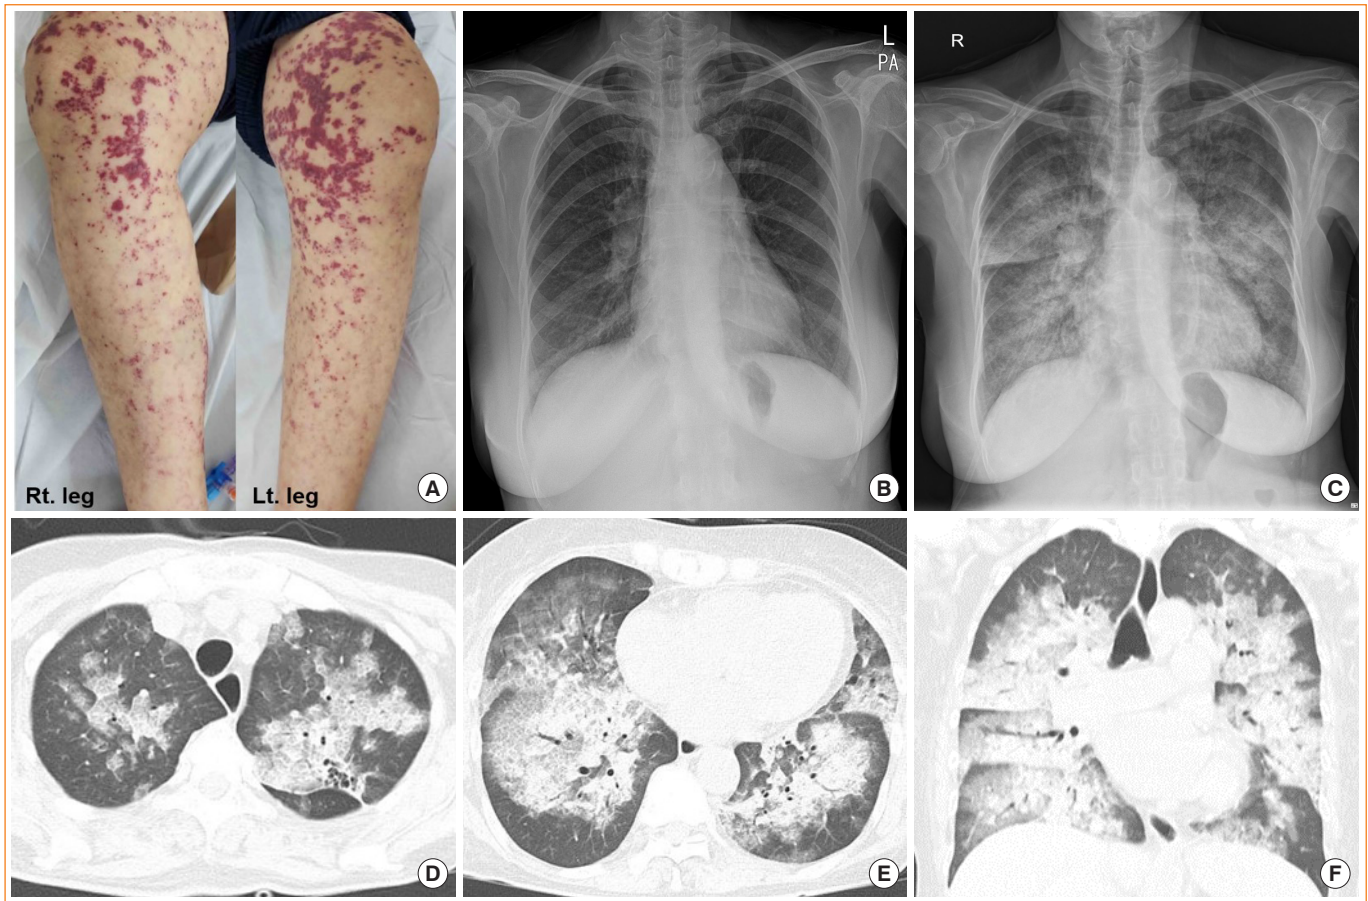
The representative images of the patient. (A) Representative images of skin lesion showed that blanching erythematous skin lesions are present on her bilateral lower extremities. (B) Initial chest X-ray at admission was normal. (C) Chest X-ray at the time the patient's symptoms worsened showed diffuse haziness in both lung fields. (D, E, F) Representative coronal or sagittal images of chest computed tomography revealed diffuse acinar opacities, ground-glass opacity, and septal thickening in both lungs.
